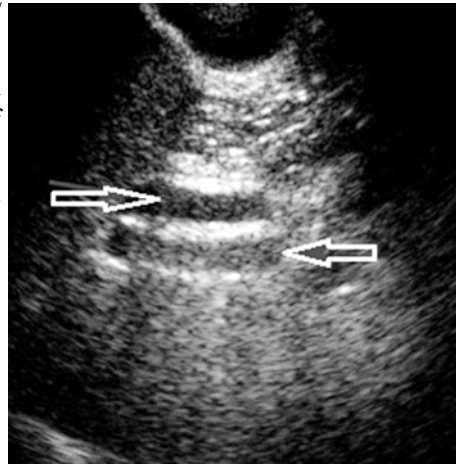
Ultrasonography: common bile duct diameter > 6 mm on US associated with high prevalence of choledocholithiasis (arrows)
